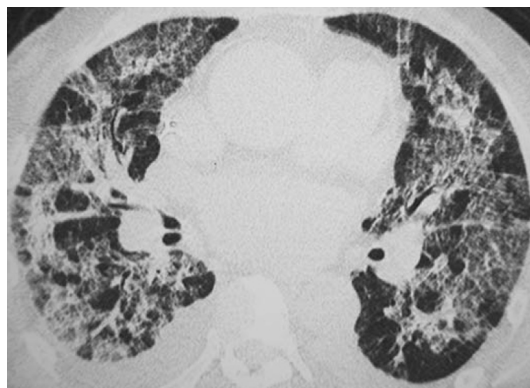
ES in 46-year-old woman with non-Hodgkin lymphoma 3 weeks after allogeneic hematopoietic stem cell transplantation. High-resolution computed tomography scan shows bilateral areas of consolidation having peribronchovascular and subpleural distribution. Note right pleural effusion. (From Franquet T, Müller NL, Lee KS, et al. Pictorial essay. High-resolution CT and pathologic findings of noninfectious pulmonary complications after hematopoietic stem cell transplantation. *Am J Roentgenol* 2005;184:629-37. Reprinted with permission from the American Journal of Roentgenology.)
